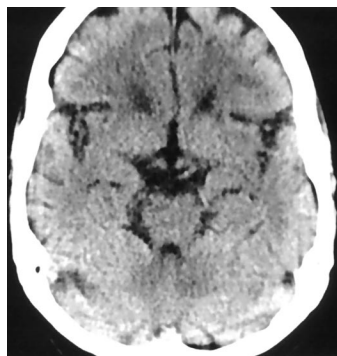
Initial computed tomographic scan, demonstrating no evidence of acute infarction, intracerebral hemorrhage, or aneurysm.
